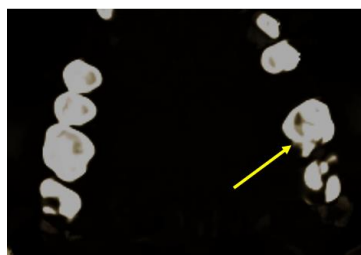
CT slice of tooth #26.
